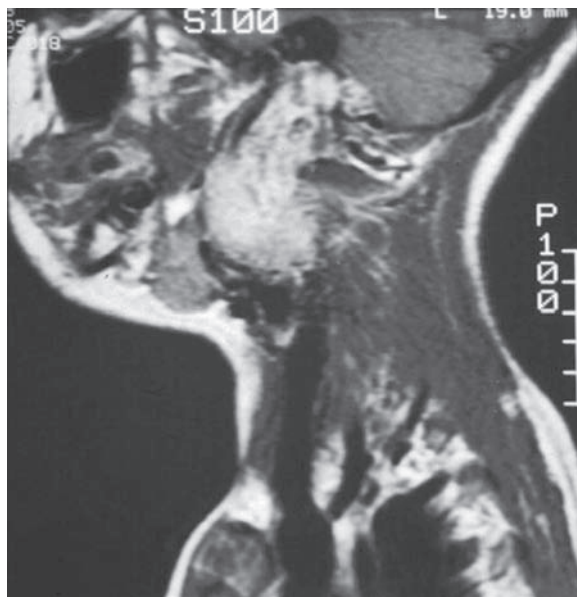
Sagittal MRI demonstrating intravagal paraganglioma
